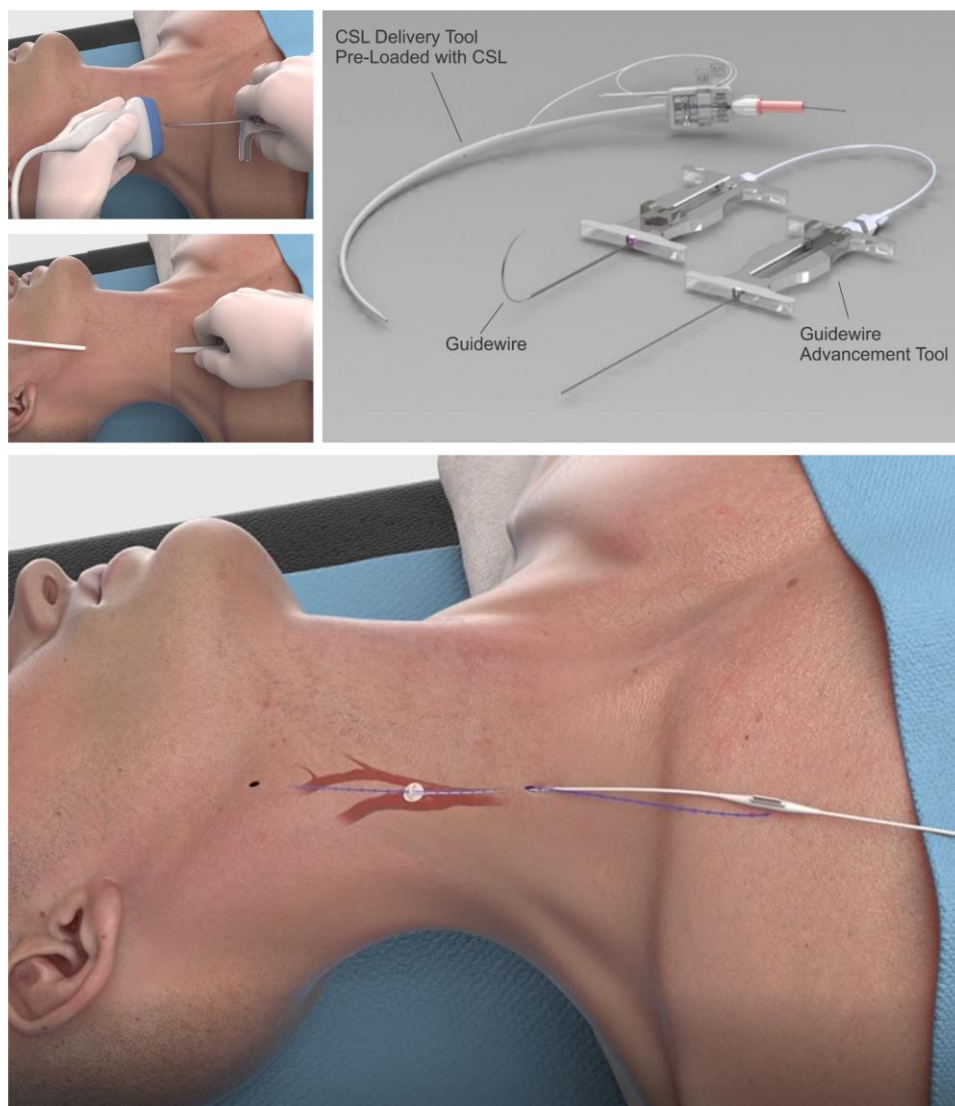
Minimally invasive technique using ultrasound imaging to guide placement of the stimulation lead near the targeted carotid baroreceptors (Courtesy L. Gaelle, CVRx).
